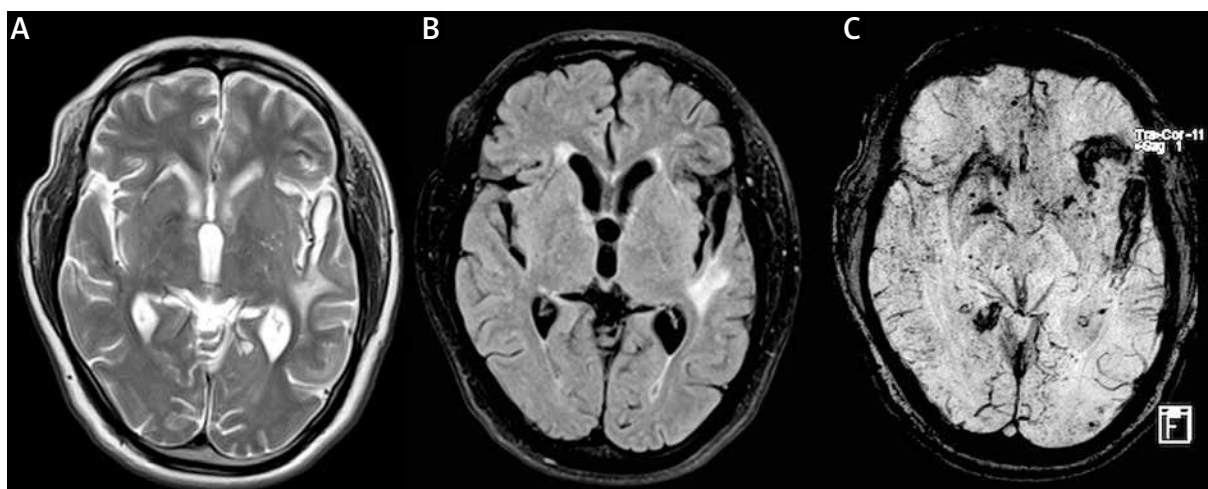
T2 weighted MR (A), FLAIR (B) and susceptibility weighted images (C) showing bilateral supratentorial white matter lesions, along with micro- and macro-haemorrhages.
